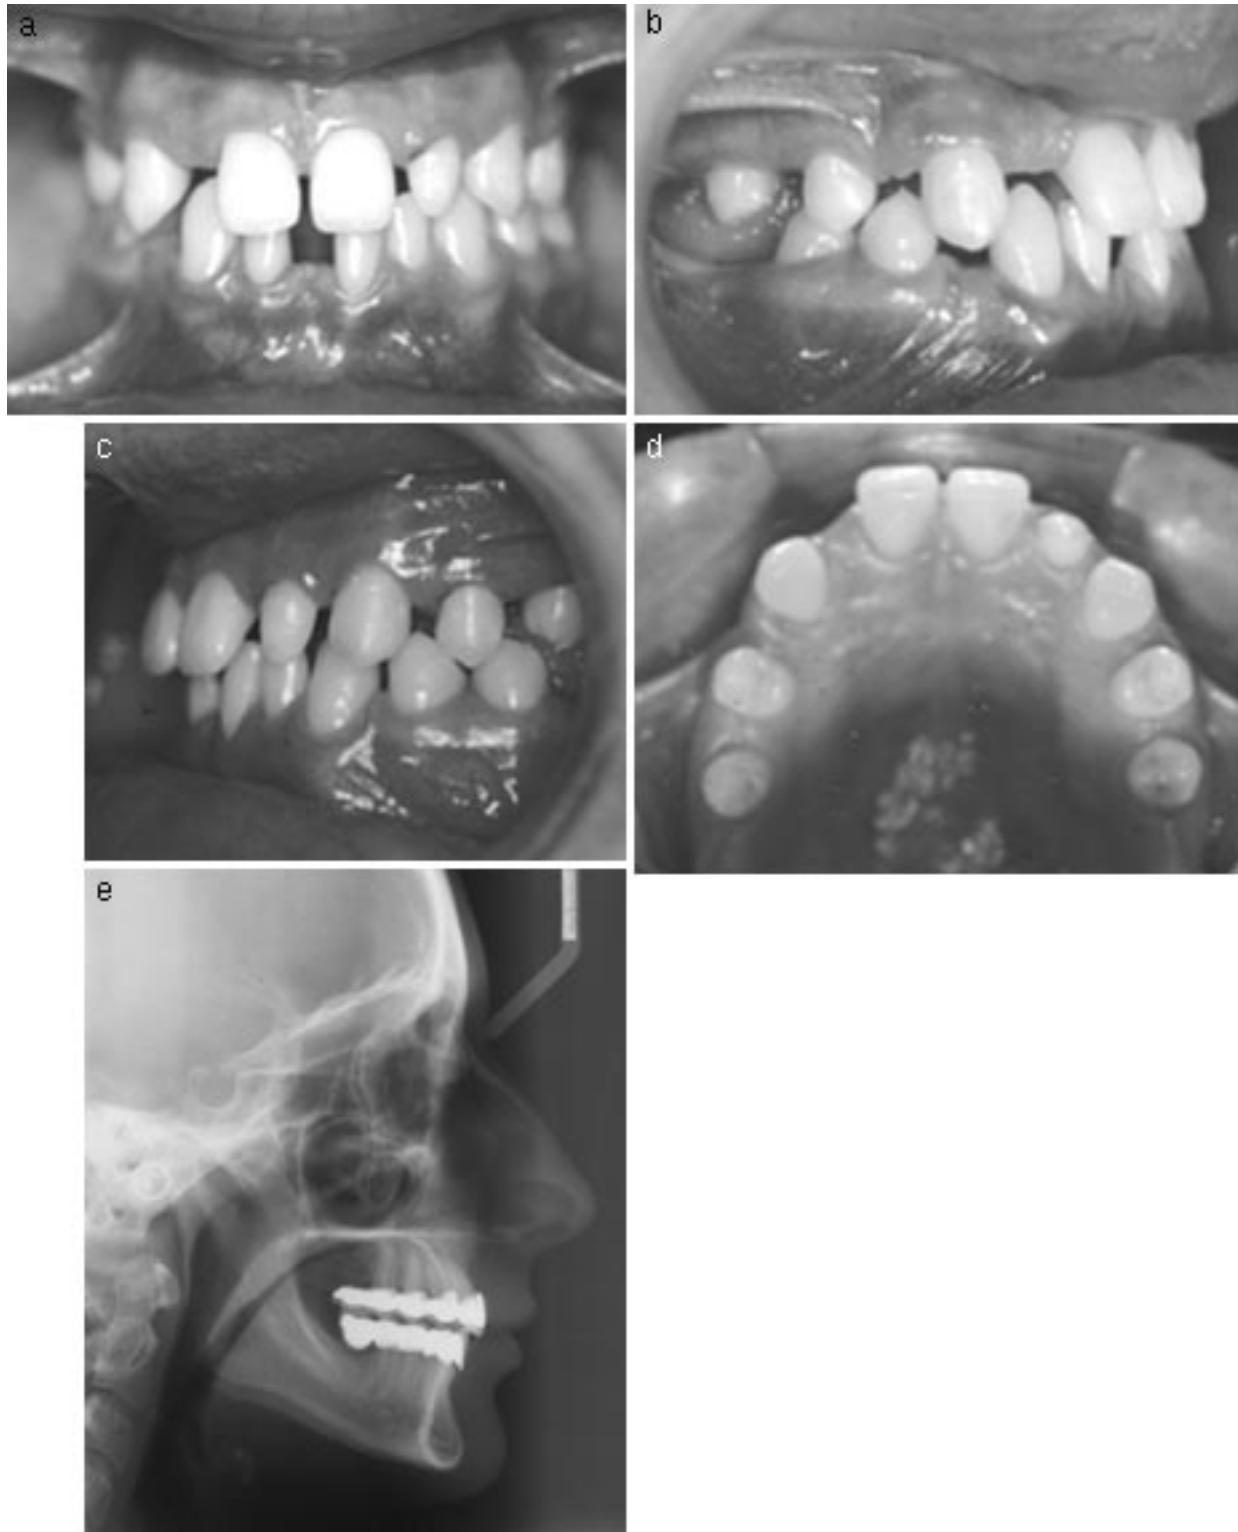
(A–E) Posttreatment intraoral photographs and cephalometric radiograph. Note the distalization of upper second premolars and correction of functional midline shift due to the expansion of the maxilla.
